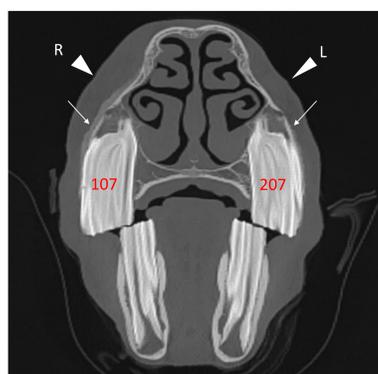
Transverse and sagittal reformatting of computed tomography images of the head in detail algorithm. Arrows: mild and irregularly margined periosteal reaction of the maxillary bones (left) and rostral mandible (right); arrowheads: adjacent subcutaneous swelling.
